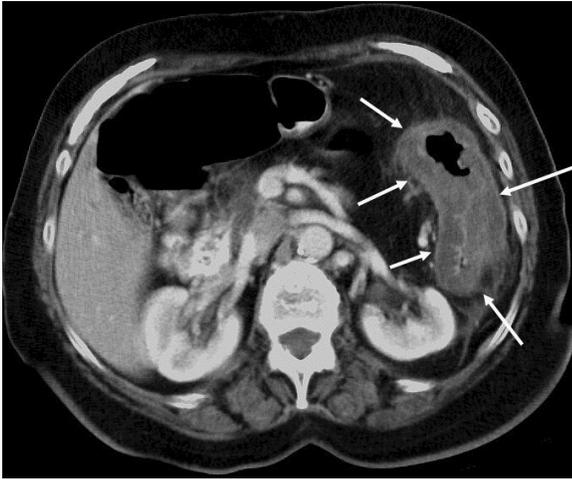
CT scan that demonstrates diffuse concentric wall thickening of the splenic flexure (white arrows) in this patient with ischemic colitis.
